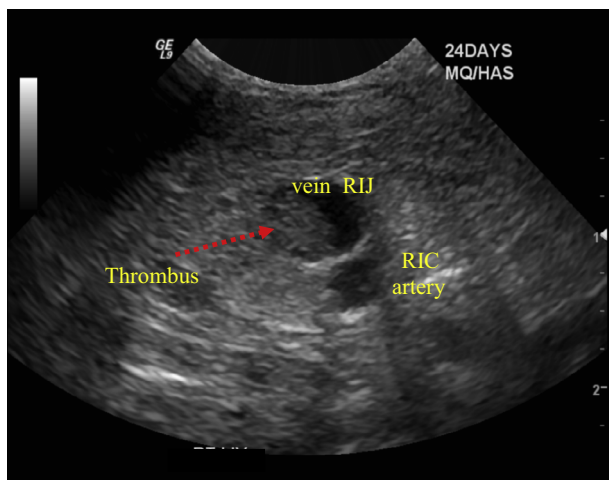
Ultrasound picture showing short axis view for the neck vessels with partial thrombosis of the right internal jugular vein. RIJ: Right internal jugular, RIC: right internal carotid.
